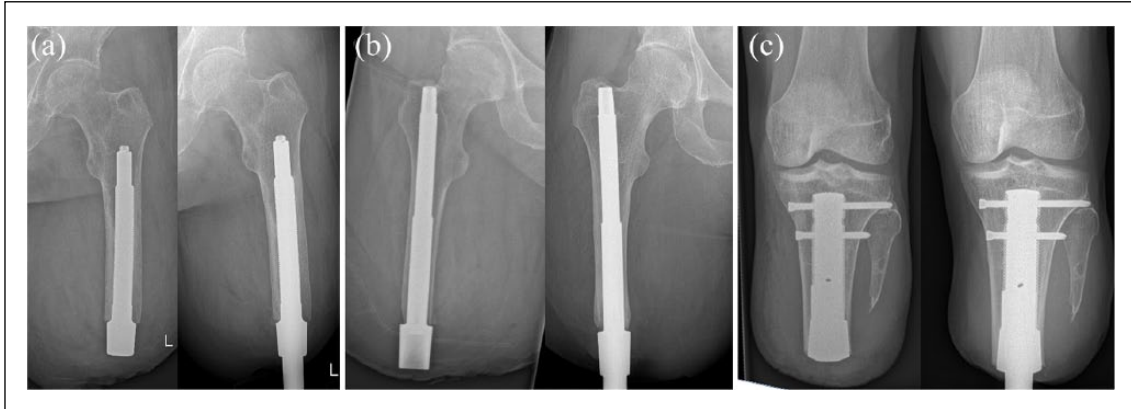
Radiographs of the used types of osseointegration implants: (a) integral leg prosthesis; (b) osseointegrated prosthetic limb; (c) patient-specific implant. Left: intramedullary stem immediately postoperatively and right: osseointegrated implant at the 12-month follow-up.
